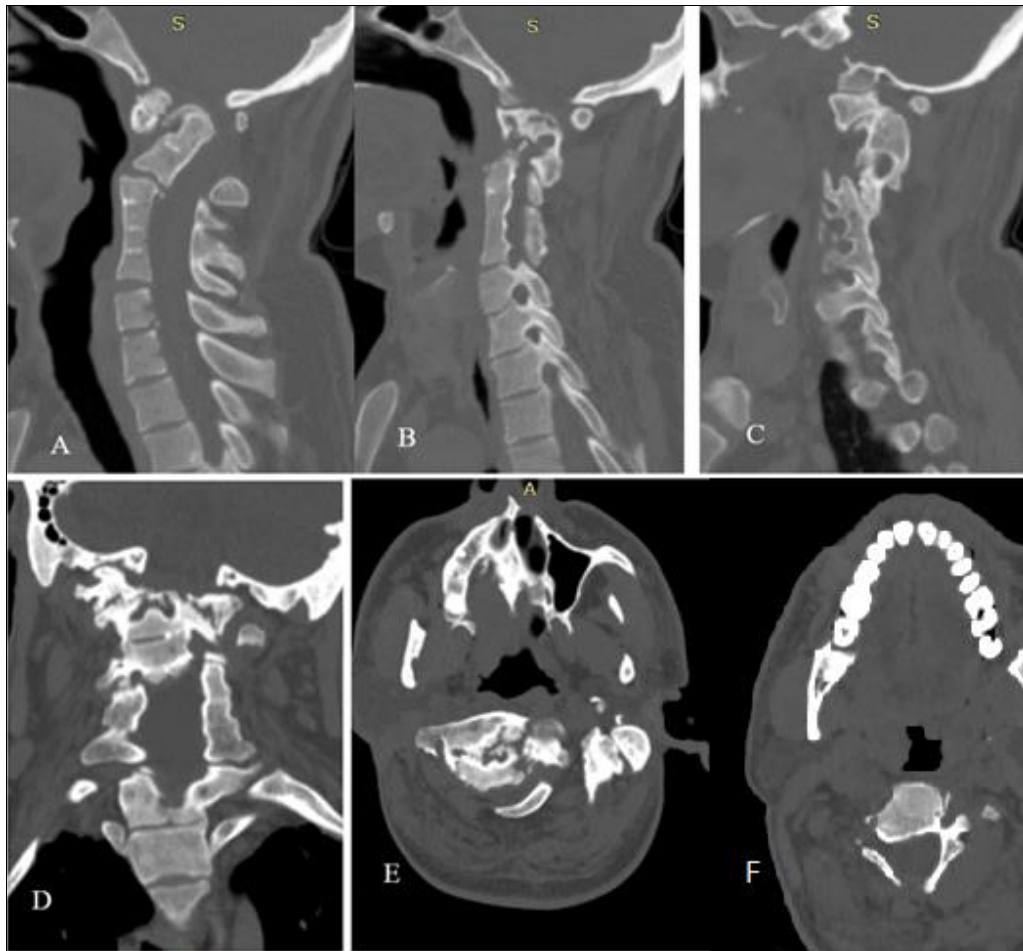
CT scan showing (A) posterior displacement of fused C2-C3 over C4-C6 segment. Os odontoideum is visible above anterior C1 arch. (B), (C) shows the degeneration and vertical orientation of right and left C1-C2 facet joints. (D), (E) shows coronal and axial view of C1-C2 anatomy. (F) shows thin C3 pedicles and lateral mass.
